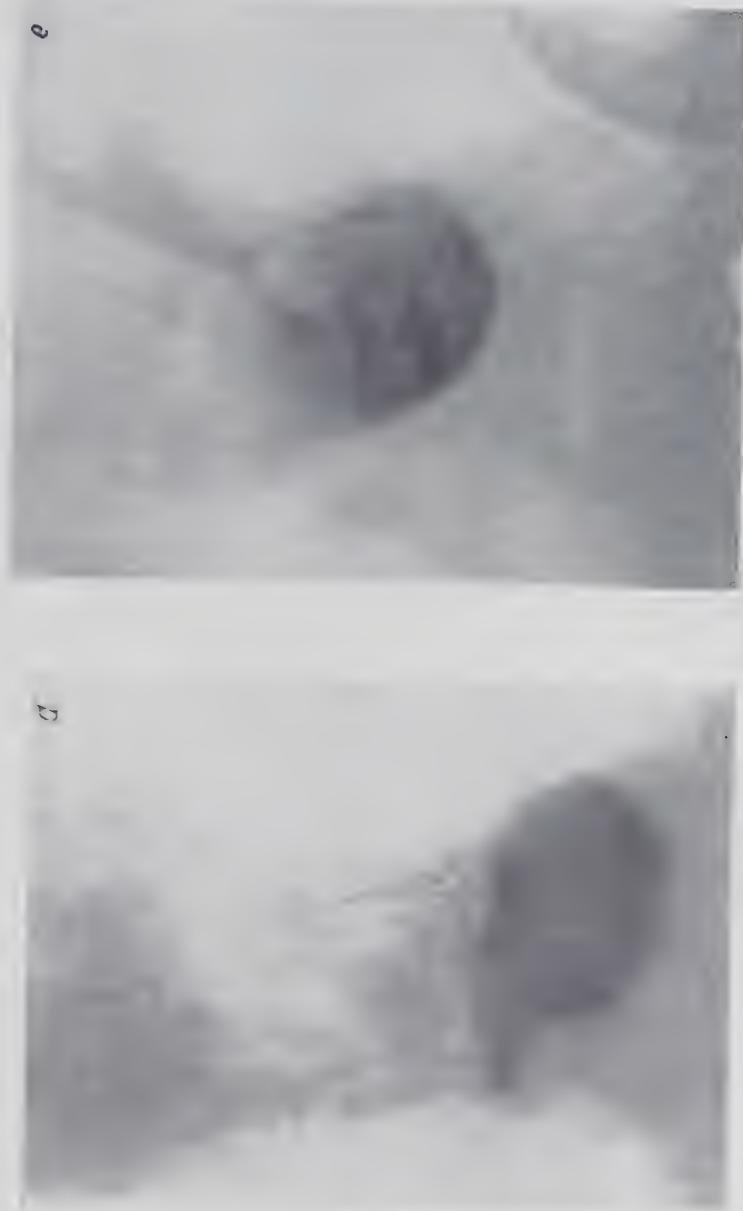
Roentgenogram of the stomach of subject D
